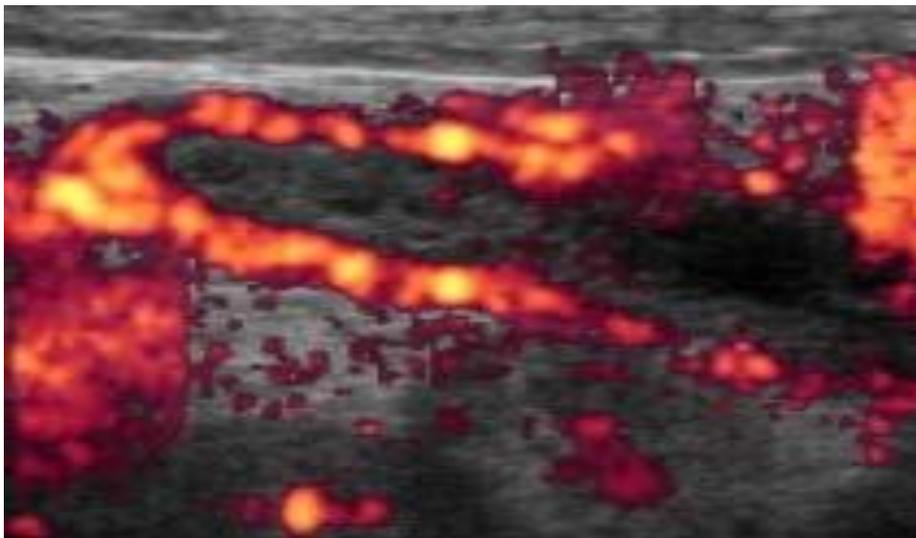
Phlegmonous appendicitis. Color Doppler ultrasonographic image demonstrating mural hyperemia.
